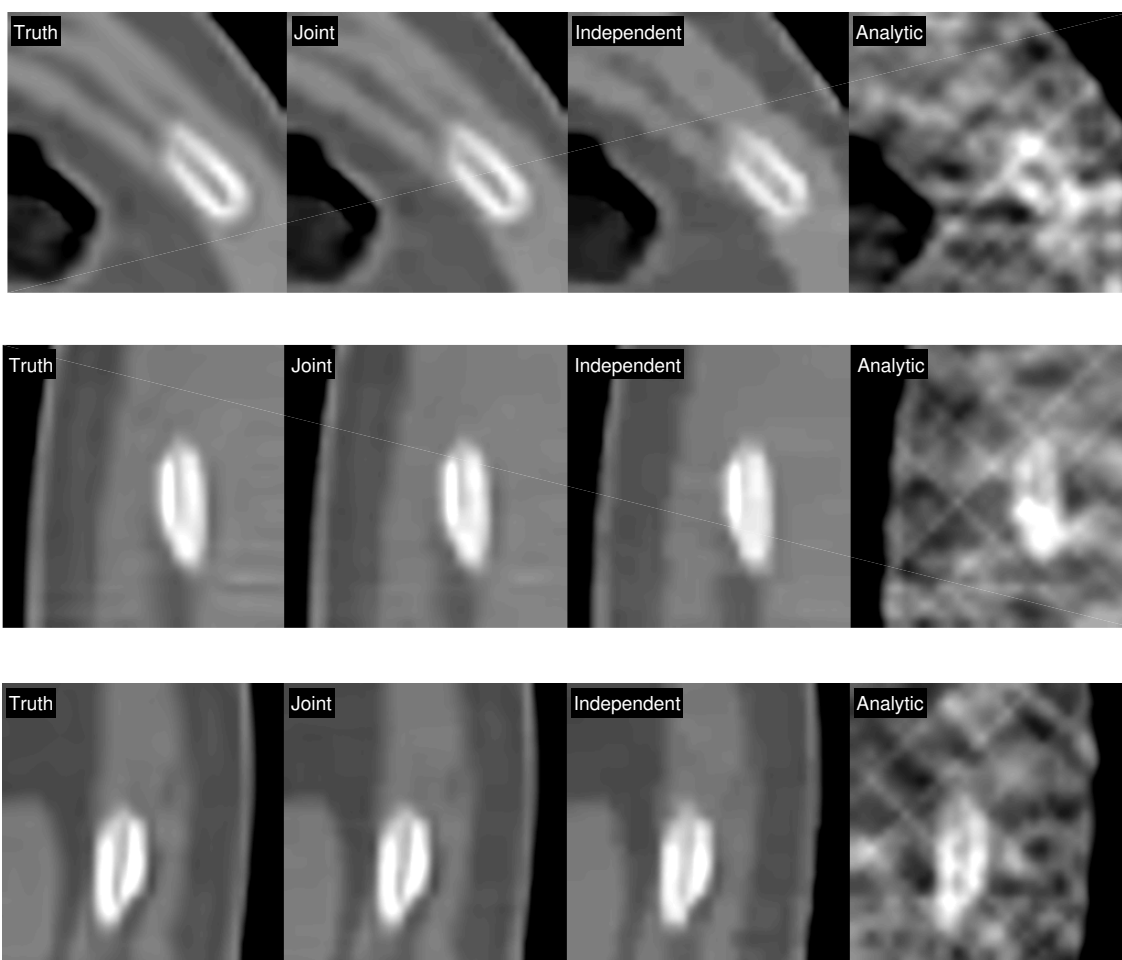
ROI comparison for CT images with all three ROIs being defined in Fig. 5.4 shown in red; All ROIs are zoomed in with zoom factor of $8\times$. Display window is $[0\ 1]$.
